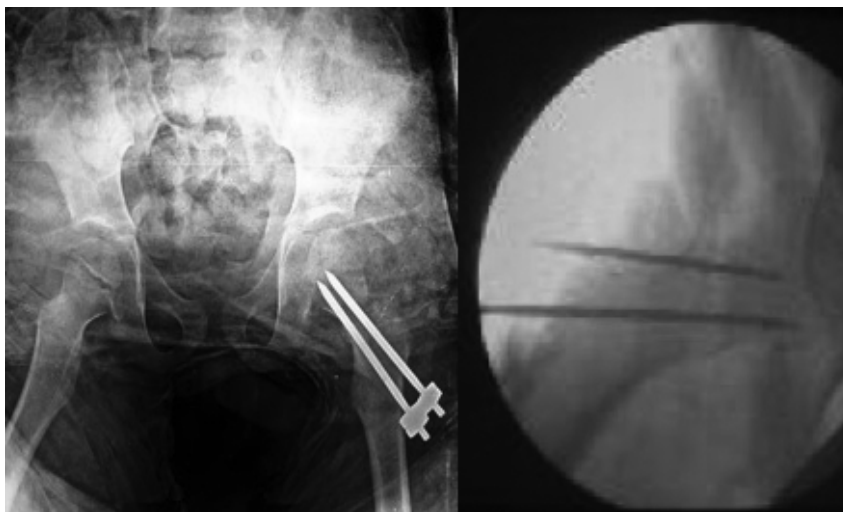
Immediate postoperative radiograph and intra-op c-arm.
